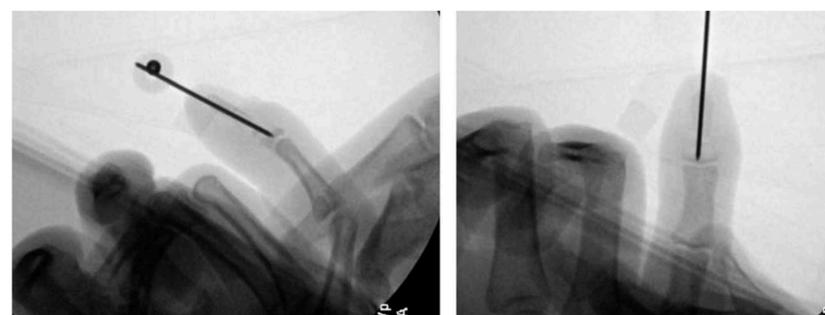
Right hand, intraoperative radiographs of open reduction internal fixation of an unstable Seymour fracture.
